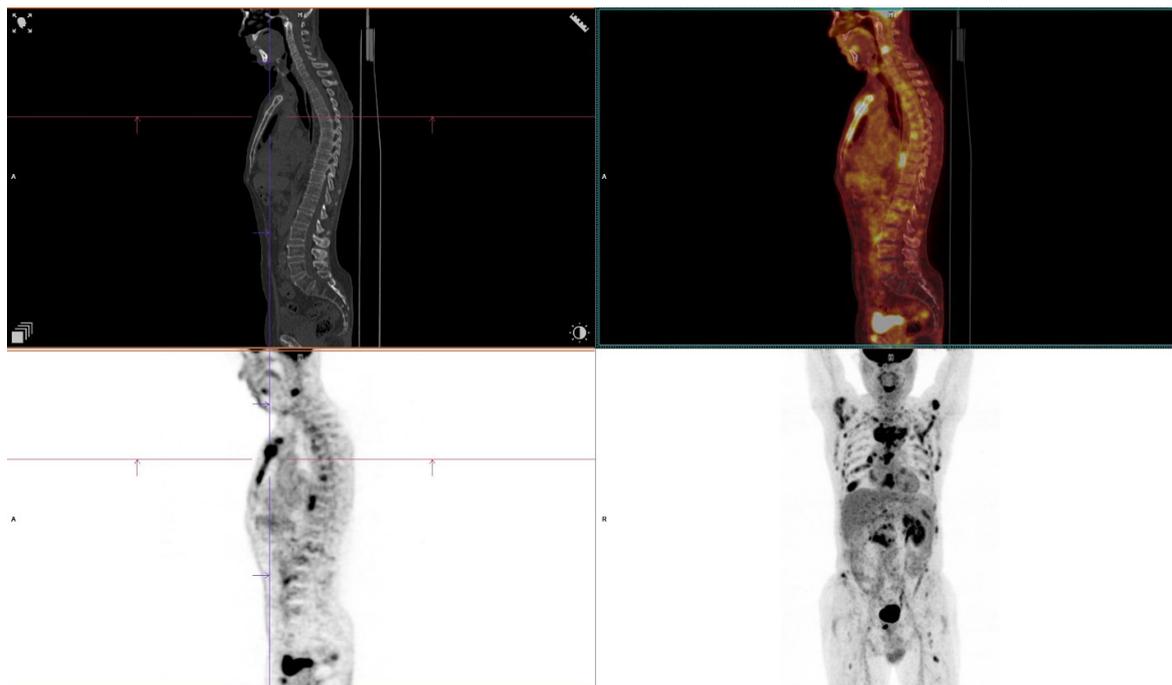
Sagittal plane of unenhanced low dose CT, PET, fused PET/CT and MIP (maximal intensity projection). Multiple zones of increased uptake in bones and lymph nodes.
